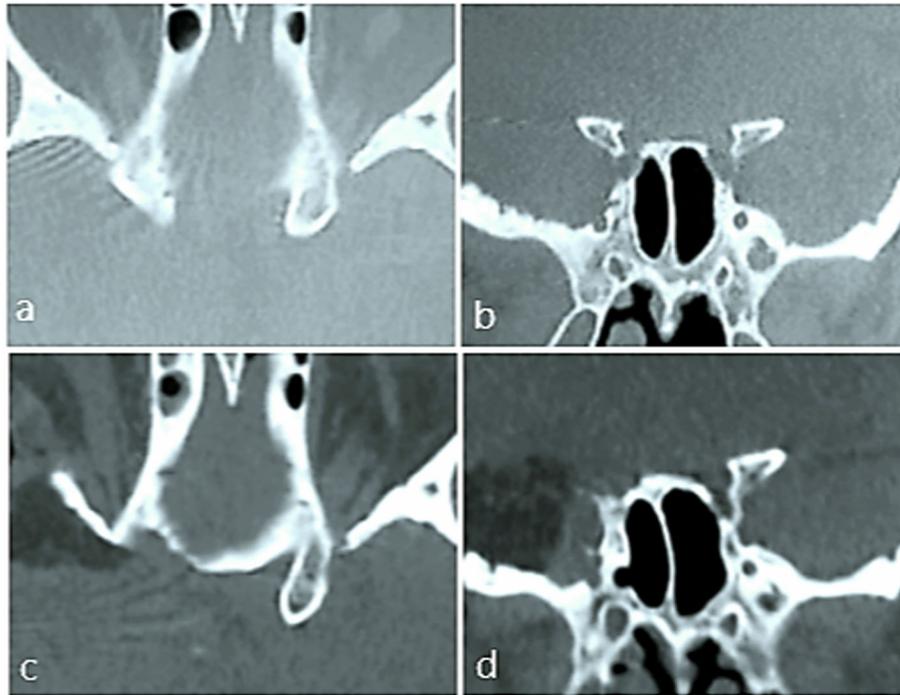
a–d Preoperative and postoperative helical bone window CT scan after right extradural anterior clinoidectomy for ACM patient. a, b Preoperative axial and coronal view, respectively. c, d Postoperative axial and coronal view showing the extent of bone drilling involving the right ACP, the optic canal roof, and the optic strut
